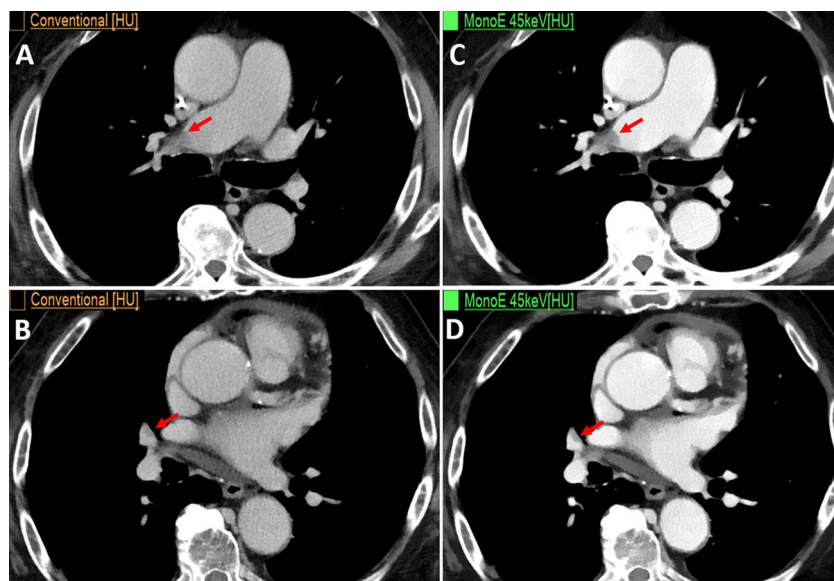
Male, aged 80, with stage IV adenocarcinoma of the pancreas. CT reassessment. (A and B) Conventional axial CT images in venous phase. (C and D) Low-energy monoenergetic images (45 keV), showing filling defects in the pulmonary arteries compatible with acute pulmonary thromboembolism (arrows), which are barely visible on conventional CT (arrows).
